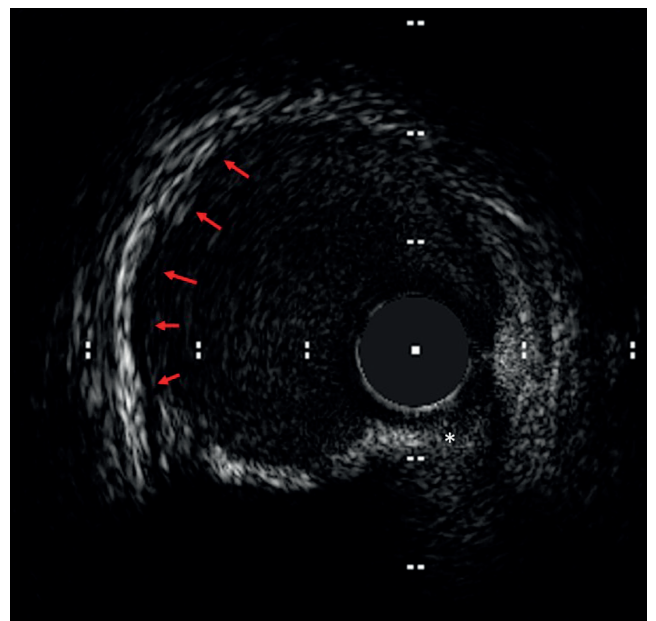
Deep calcification (red arrows), wire artifact (white asterisk) – intravascular ultrasound
